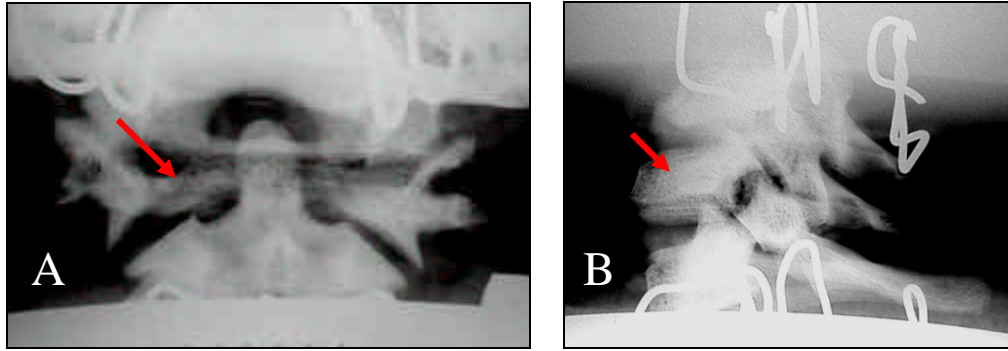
Post-injury radiographs. (A) Oc-C2 segment showing C1 burst fracture and separation of the C1-C2 facet. (B) C6-T1 segment exhibiting a C7 burst fracture with associated lateral mass fracture.
